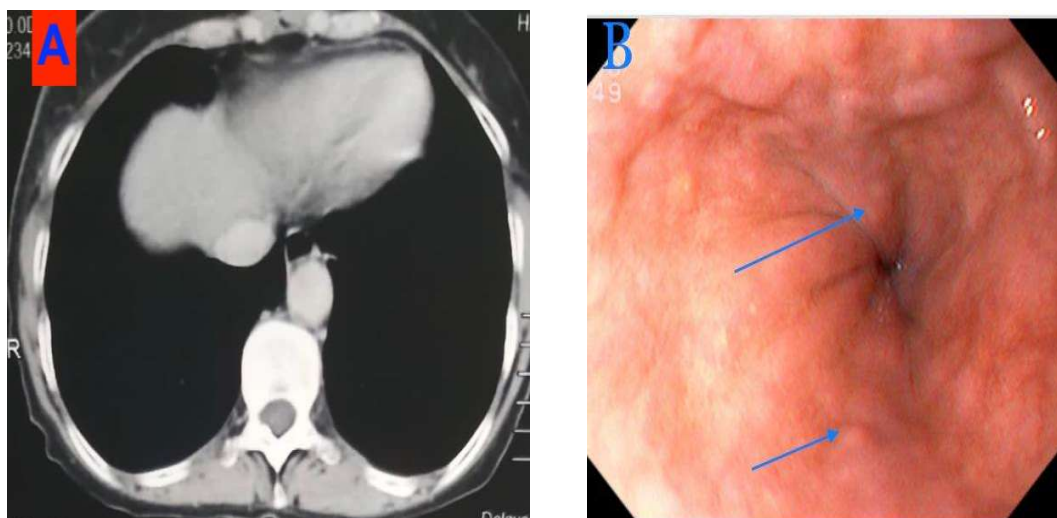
48 years old female patient with known liver cirrhosis on routine endoscopic evaluation. CT: Triphasic CT portal phase of upper abdominal cuts shows normal esophageal lumen with no evidence of varices, score 1(image A). Endoscopy findings: grade 1 esophageal varices (image B).
